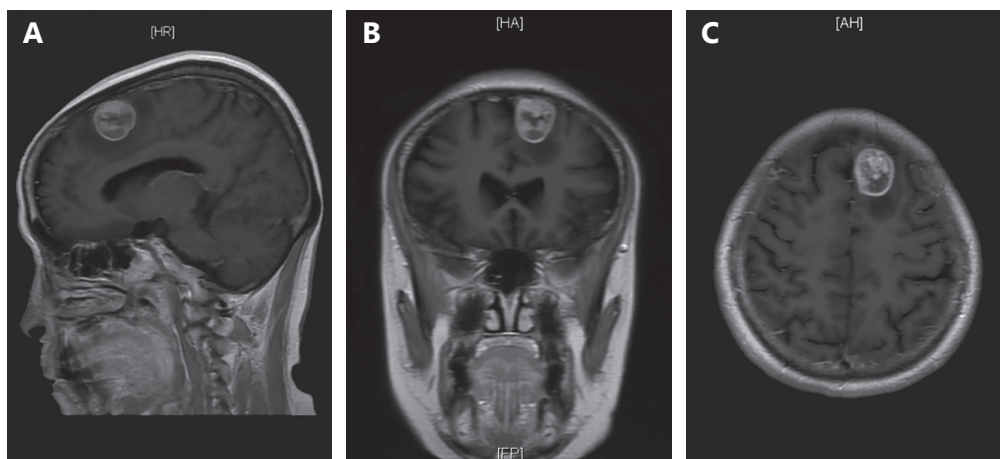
Case 1: brain magnetic resonance imaging (MRI) showed metastasis in the patient's brain in September 2015.
